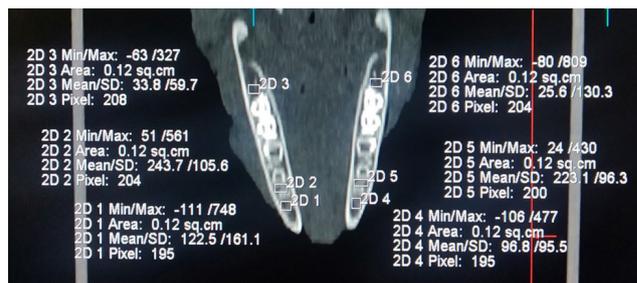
Axial section of the CT scan of sample II, indicating multiple placements of regions of interest (ROI)
